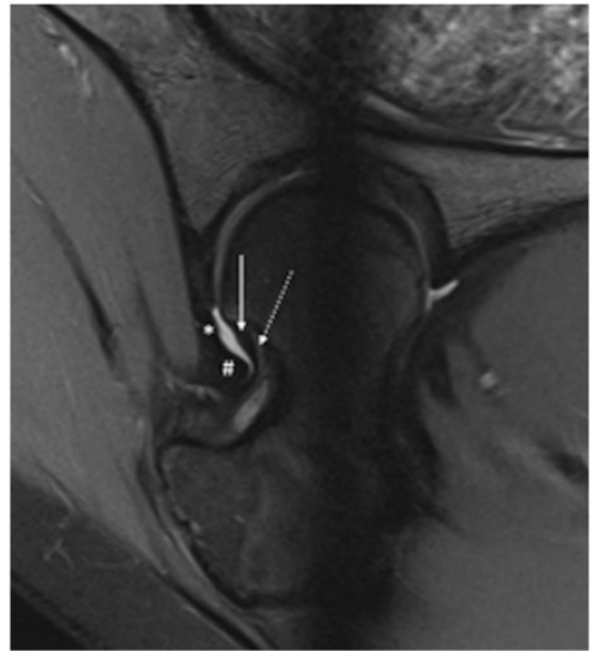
Radial magnetic resonance imaging (MRI) demonstrating that the lateral ascending retinacular vessels (dotted arrow) largely travel in the lateral synovial fold (solid arrow) and run under the zona orbicularis (#). The zona orbicularis is the condensation of the iliofemoral ligament (*) that wraps circumferentially around the femoral neck.
